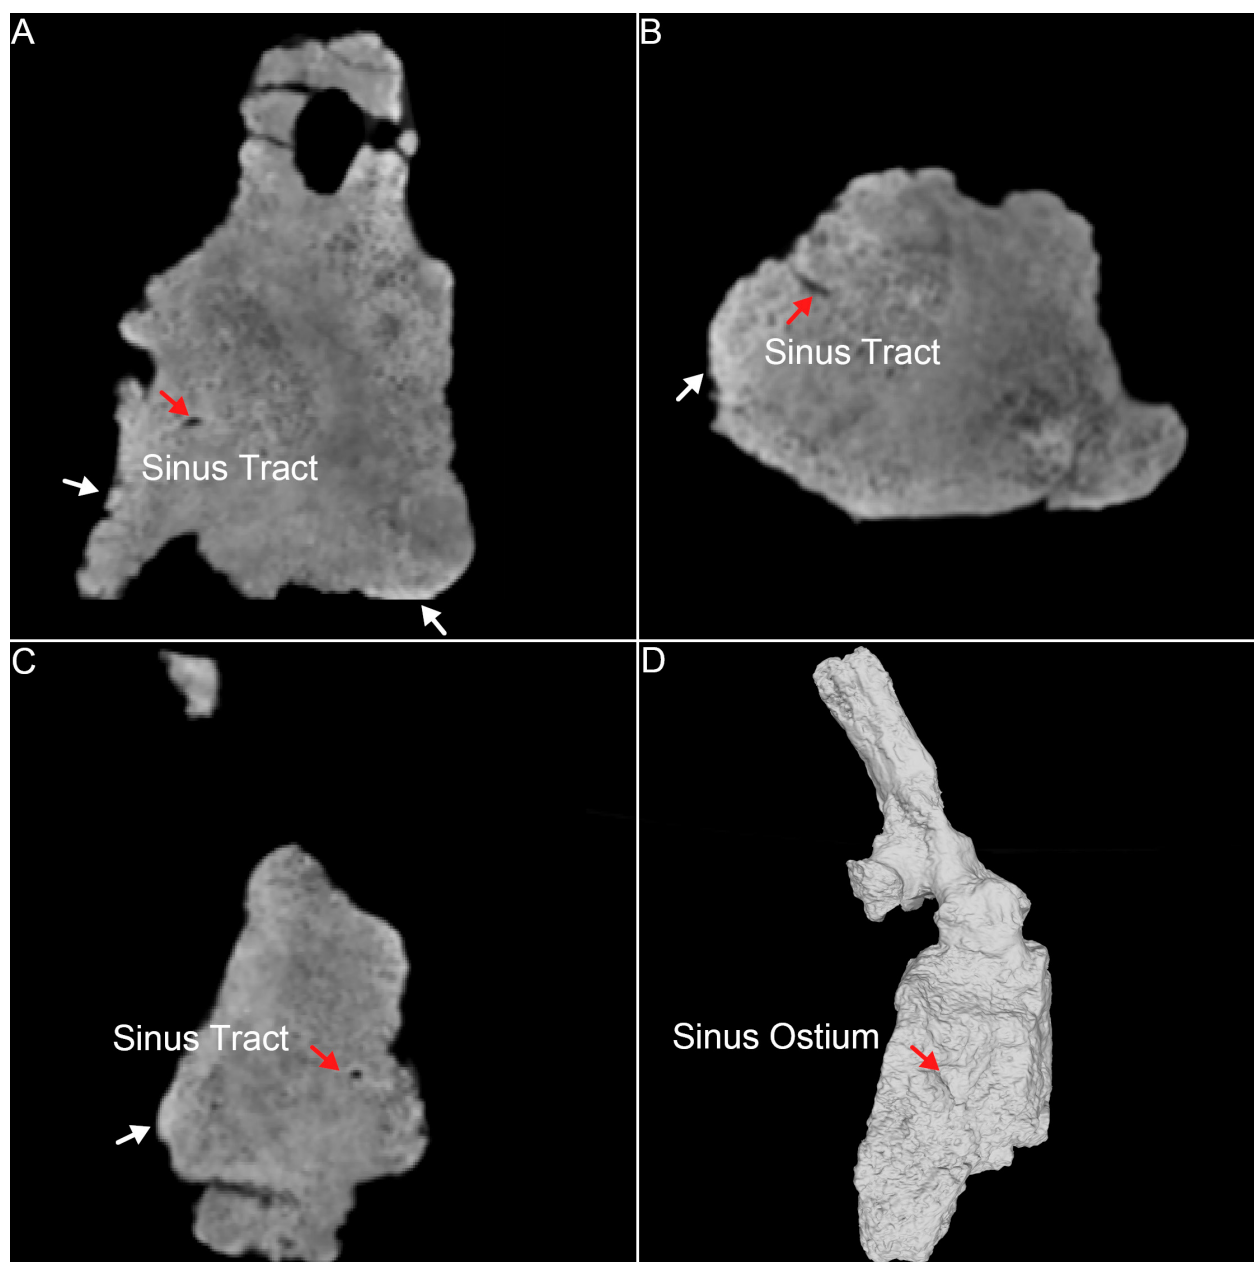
CT imaging of the seventh caudal vertebra of HS0385: A. Axial section; B. Coronal section; C. Sagittal section; and D. 3D right lateral view. Red arrows indicate the sinus tract; white arrows indicate sclerosis.
